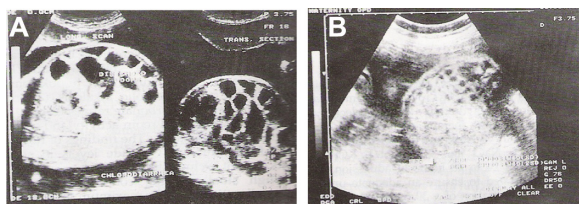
Antenatal ultrasounds. (A and B) show antenatal ultrasounds of two patients with distended fetal hypoechoic intestinal loops.
